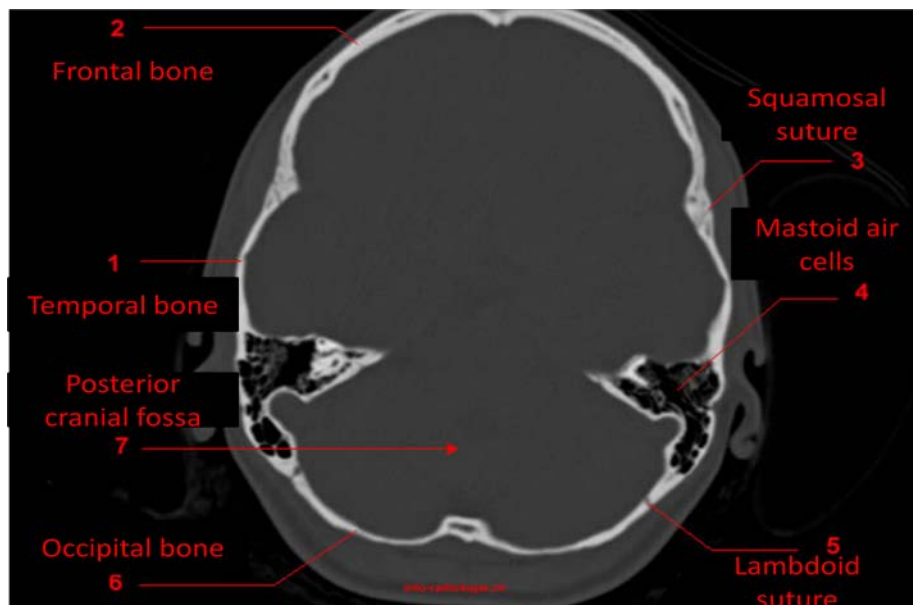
Axial CT brain bone window shows anatomical structure which can be identified.
